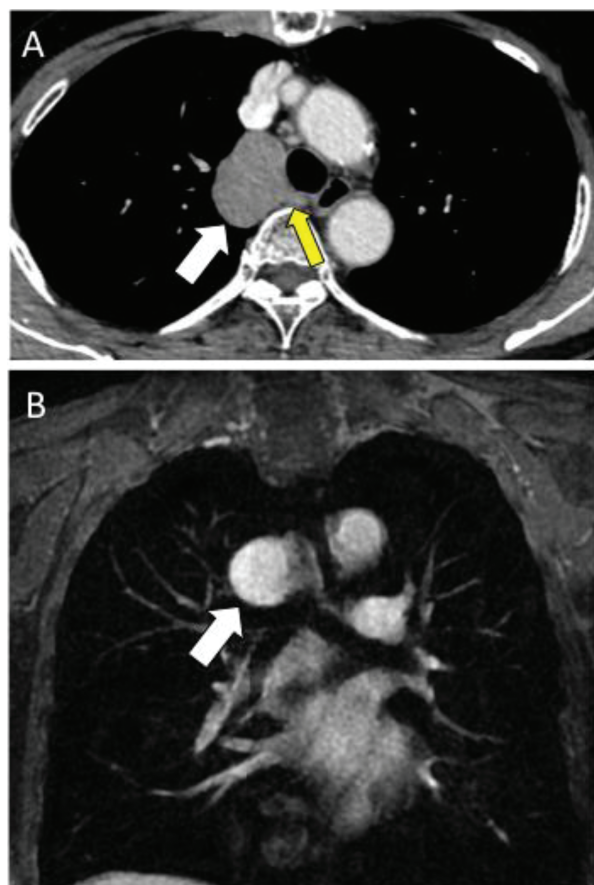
Computed tomography with single bolus of contrast (A) and magnetic resonance imaging (B) showed an azygous vein aneurysm (white arrow) connected with the azygous arch (yellow arrow).
